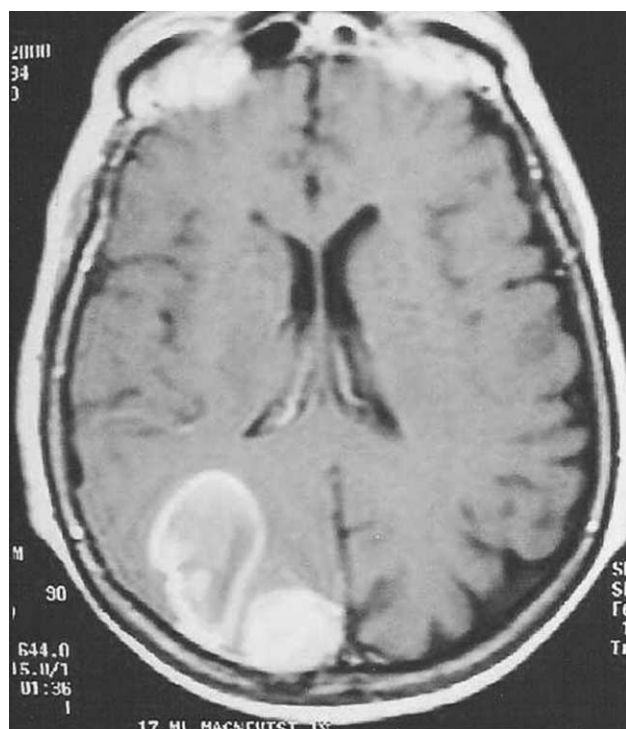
T1-weighted brain MRI with gadolinium enhancement, showing both the meningioma and the intracerebral haematoma.
